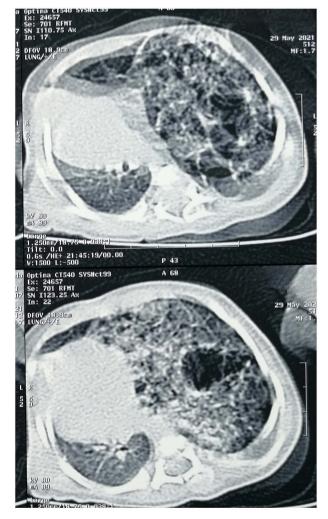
CT scan reveals several aerated cysts that are separated from the healthy lung parenchyma and linked to the bronchi.
